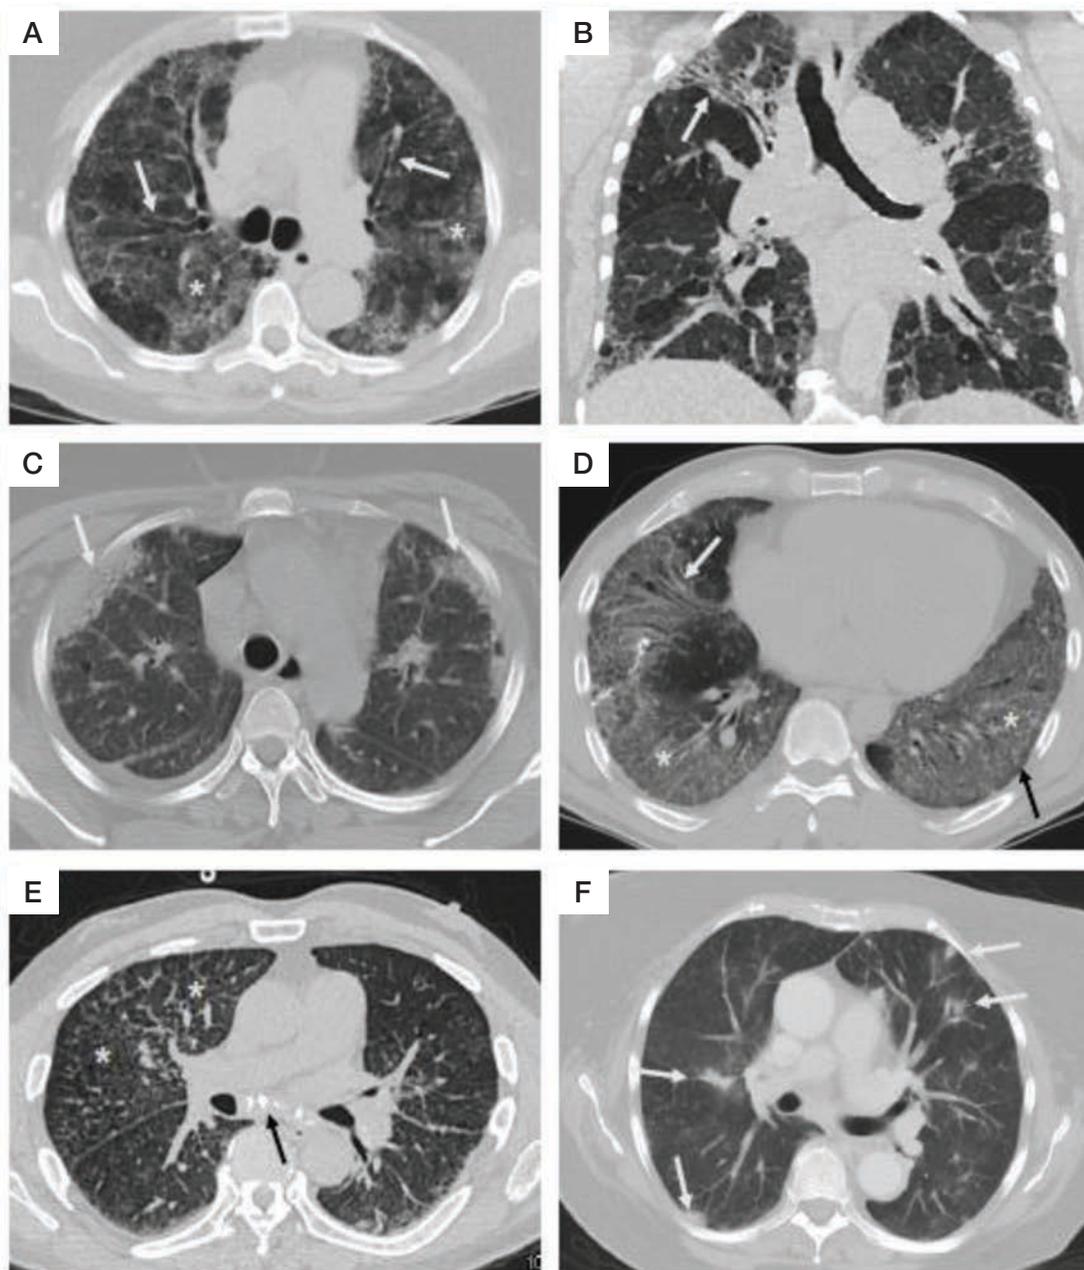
Common radiological patterns observed on HRCT imaging in various forms of ILD.
